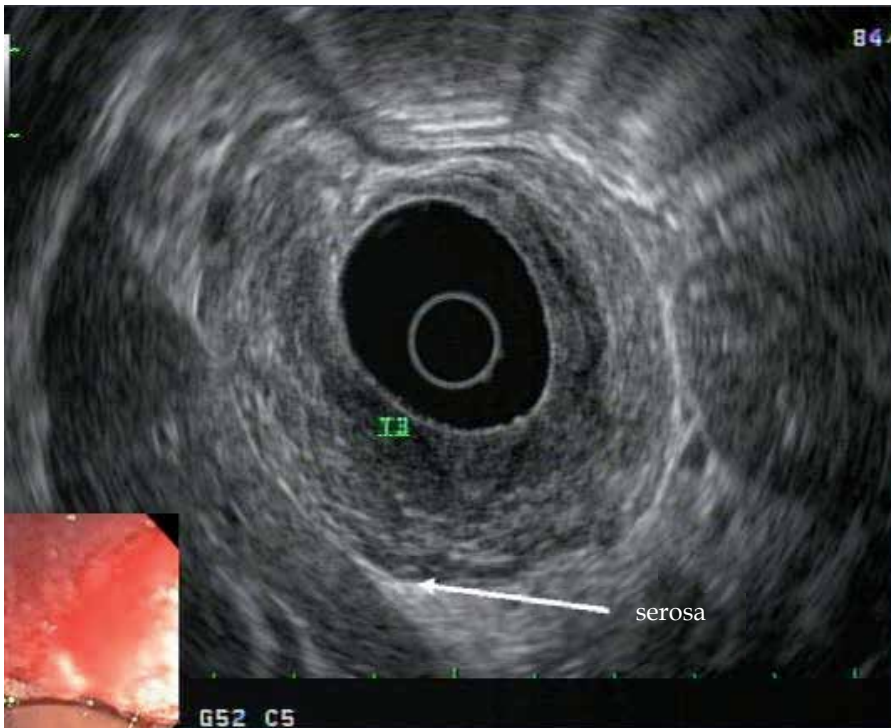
T3 gastric adenocarcinoma with infiltration of the tumor beyond the 4th sonographic layer without penetration of the visceral peritoneum.
